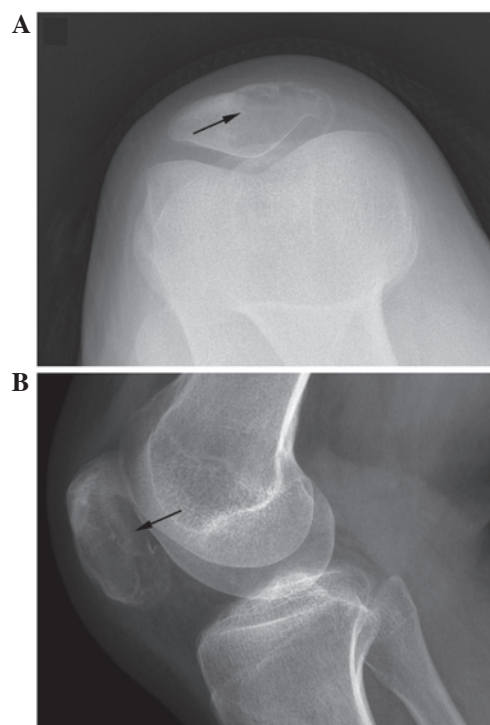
Preoperative plain radiograph. (A) Enlargement of the cystic lesion in the patella was visible on the axial view. (B) A bone translucency with peripheral rim change is observed at the lateral bottom part of the patella. Arrows indicate the lesion.
